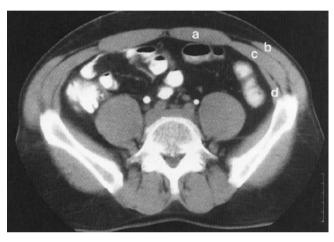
A CT scan demonstrating normal anatomy of the muscles of the abdominal wall. *a*, Rectus abdominis muscle; *b*, external oblique muscle; *c*, internal oblique muscle; *d*, transversus muscle
